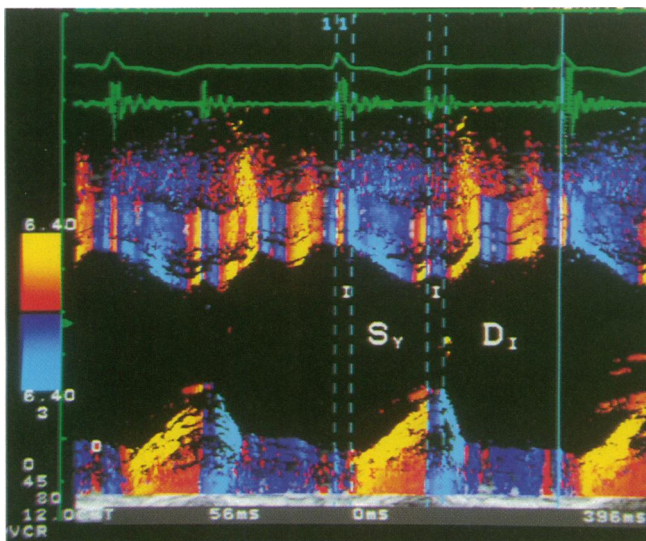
Parasternal M mode tissue Doppler echocardiogram, showing the normal contraction pattern and distribution of velocities. The highest myocardial velocities are indicated by light blue and yellow and lower velocities by dark blue and red. During systole (S_v) and early diastole (D_v) the subendocardial layers are coded with light blue and yellow, whereas the subepicardial layers are coded dark blue and red. The transmural velocity gradients in the interventricular septum and posterior wall are normal.
